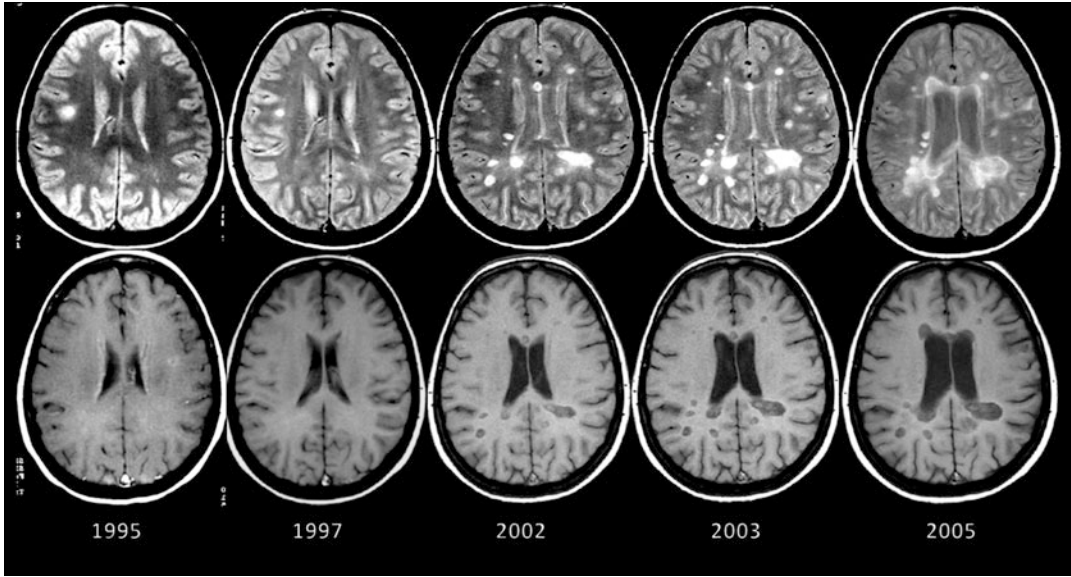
PD-weighted MR images (top row) showing the occurrence of MS typical T2/PD hyperintense lesions over time. T1-weighted images (bottom row) showing enlargement of sulci and ventricles over time consistent with brain atrophy and hypointensity of multiple lesions due to local tissue loss. (Figure kindly provided by Dr. Alex Rovira (Hospital Universitari Vall d’Hebron, Barcelona))
